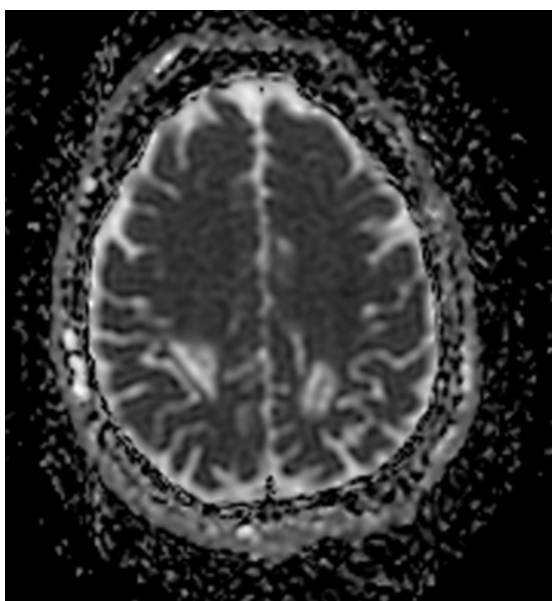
MRI images in DWI taken three months post treatment
